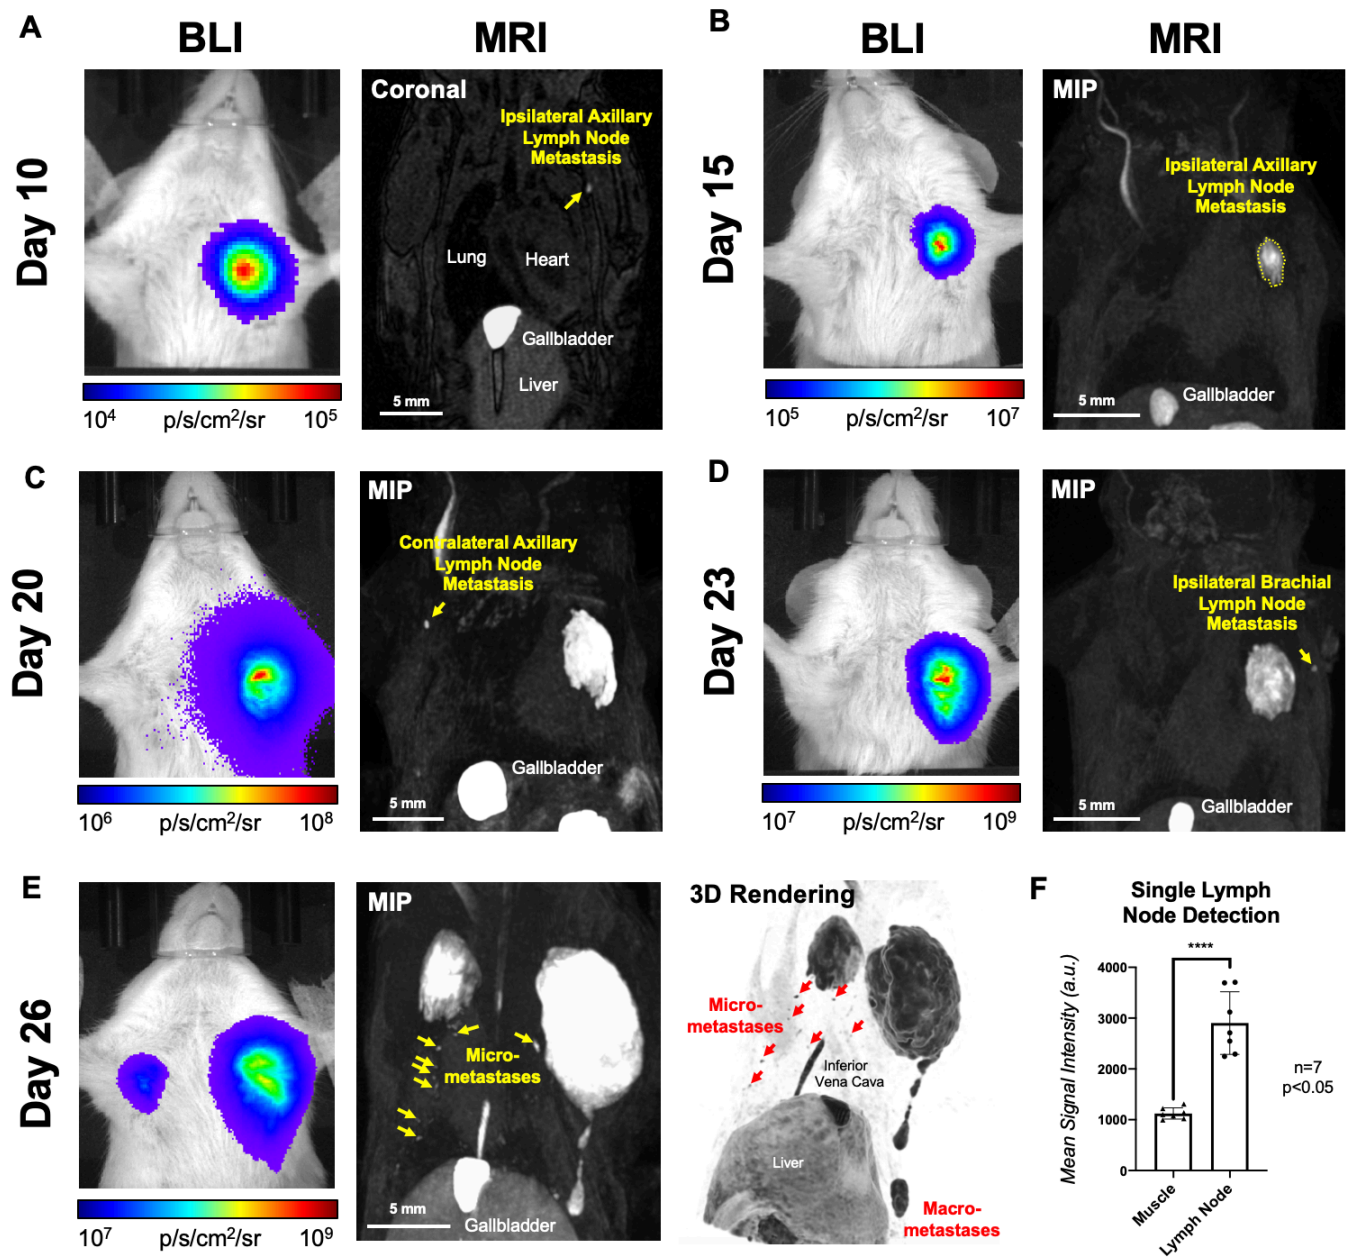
Longitudinal Tracking of Spontaneously Metastasizing Cancer Cells via Bioluminescence Imaging and Magnetic Resonance Imaging at 3 Tesla.
